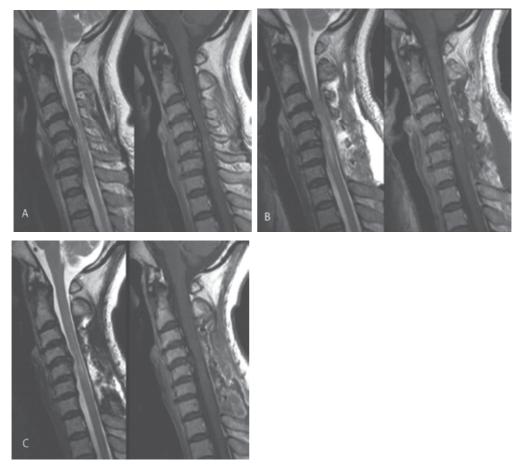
Representative case (63 years, female). A. Preoperative MRI showing spinal cord compression at C4/5 and T2 hyperintensity and gadolinium enhancement at C5. B. Postoperative MRI showing extended T2 hyperintensity and gadolinium enhancement. C. After administration of corticosteroid, T2 hyperintensity and gadolinium enhancement remarkably improved.
